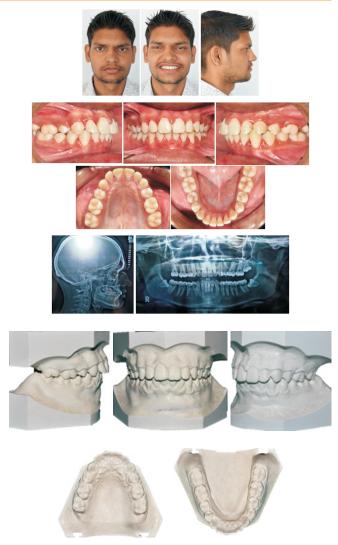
Post treatment intraoral and extraoral photographs along with post treatment radiograph.
